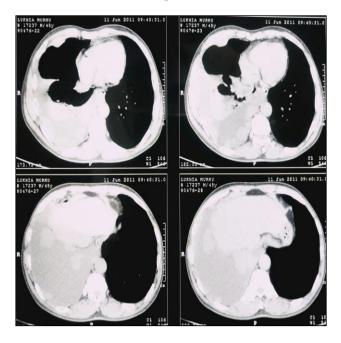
B): CT Scan showing pleural lesions as enhancing soft tissue densities along the diaphragmatic and mediastinal pleura.
